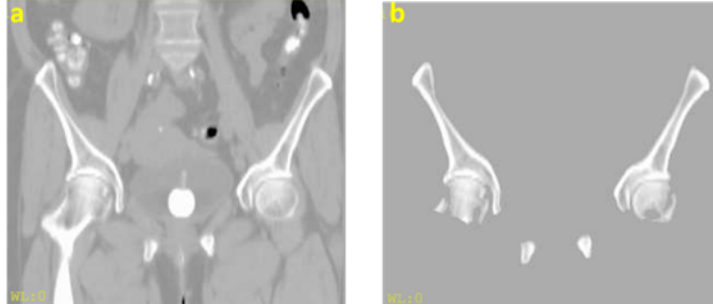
CT image (a) before and (b) after preprocessing.
